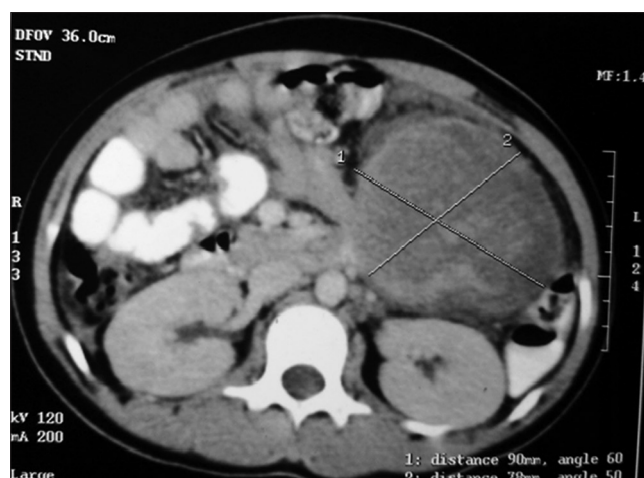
Contrast-enhanced computed tomography whole abdomen showing well-defined mildly heterogeneously enhancing lesion in left hypochondriac region
